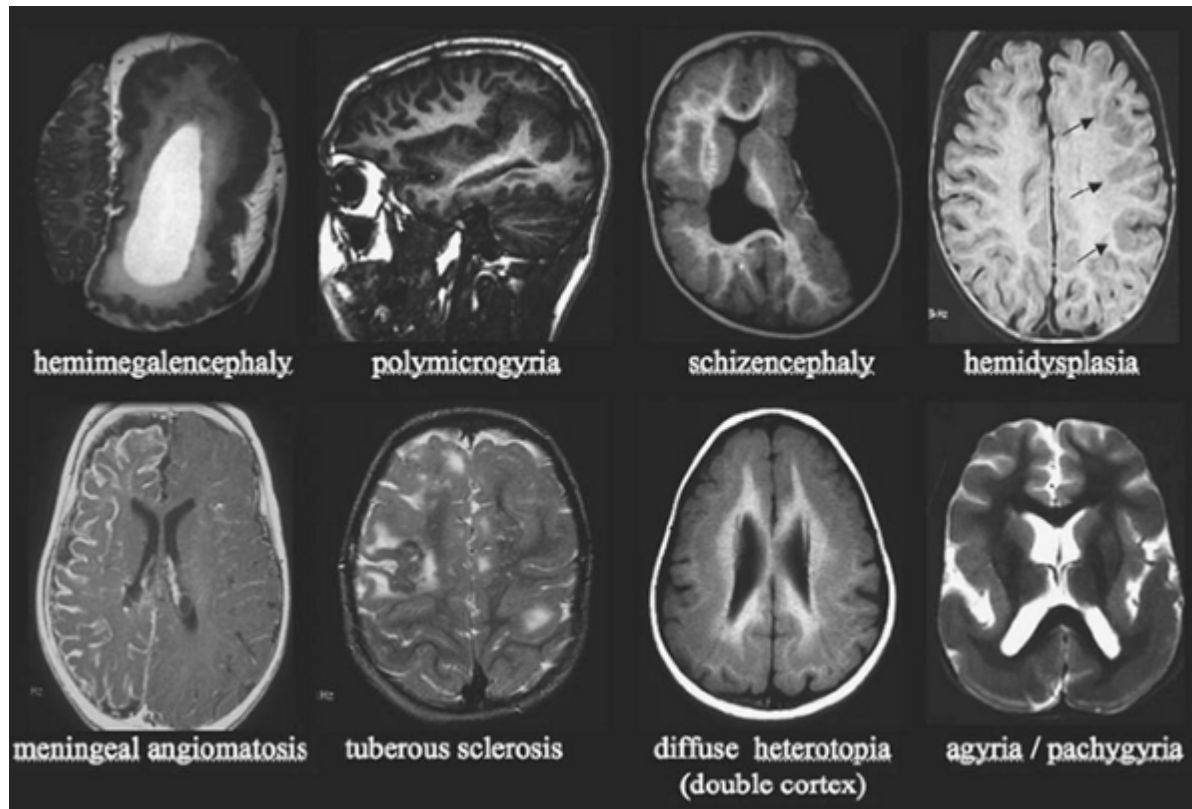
A range of diffuse pathologies that can be seen on magnetic resonance imaging that are the cause of epilepsy. Perisylvian polymicrogyria is usually best appreciated on the parasagittal images.
